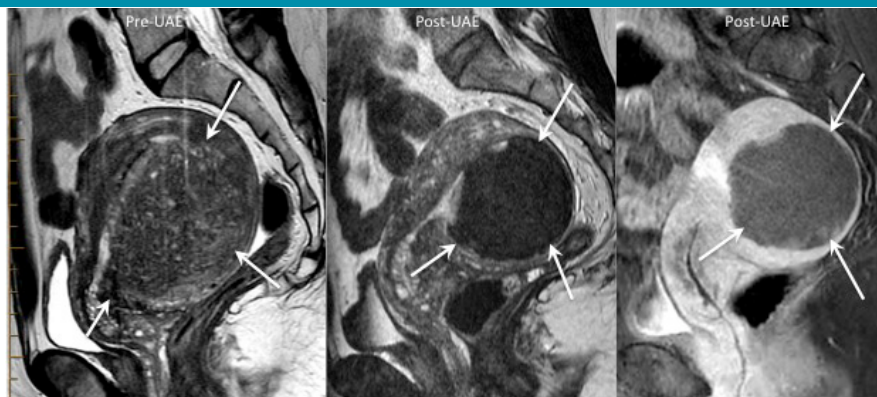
MRI showed a large area of adenomyosis (arrows) in the back wall of the uterus; 6 months post UAE MRI showed infarction of focal adenomyosis (arrows), and shrinkage from 272ml to 115ml
